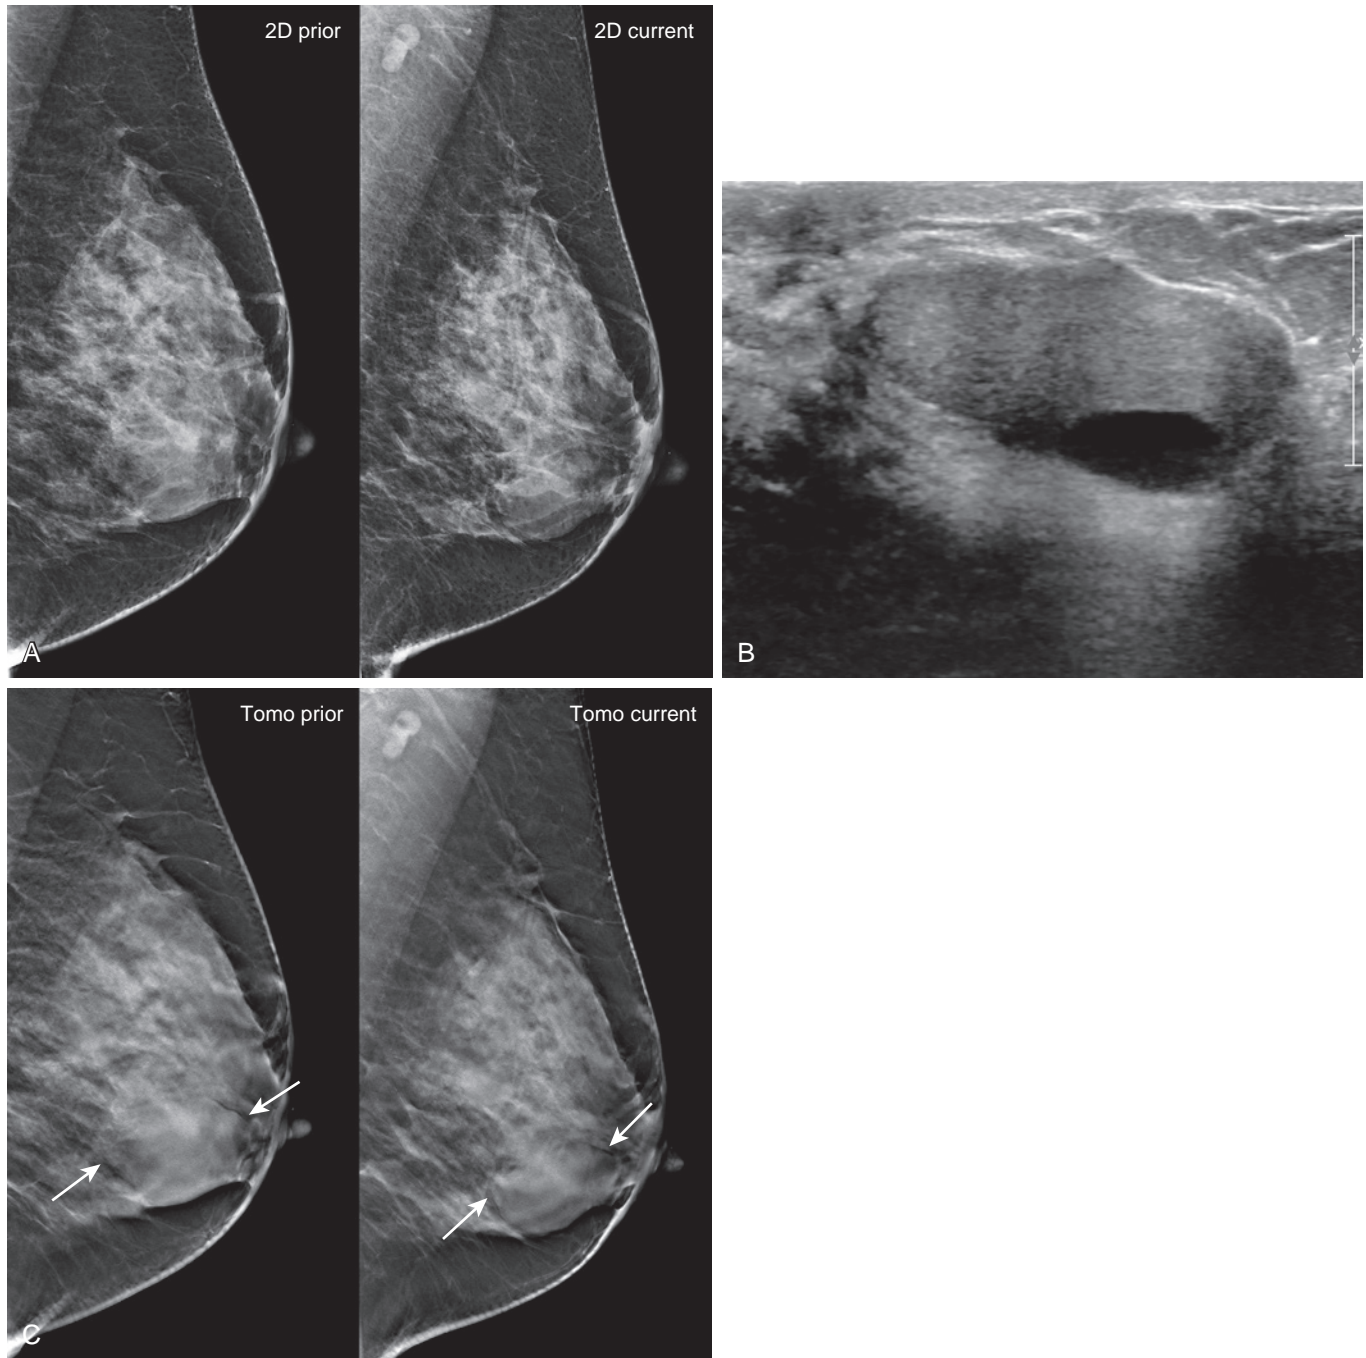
Tomosynthesis reduces additional imaging and follow-up. Screening mammogram in a 49-year-old woman with dense breast tissue and a family history of breast cancer. (A) Left breast MLO 2D views from 1 year prior and current do not permit complete assessment of a large mass proven to be PASH (pseudoangiomatous stromal hyperplasia) on a previous biopsy. (B) Ultrasound performed 2 years prior shows the corresponding oval, hypoechoic, wider than tall mass. (C) The circumscribed margins and size (*arrows*) can be well seen on prior and current tomosynthesis images, which allow confident assessments of the mass as stable; repeat ultrasound was unnecessary.
